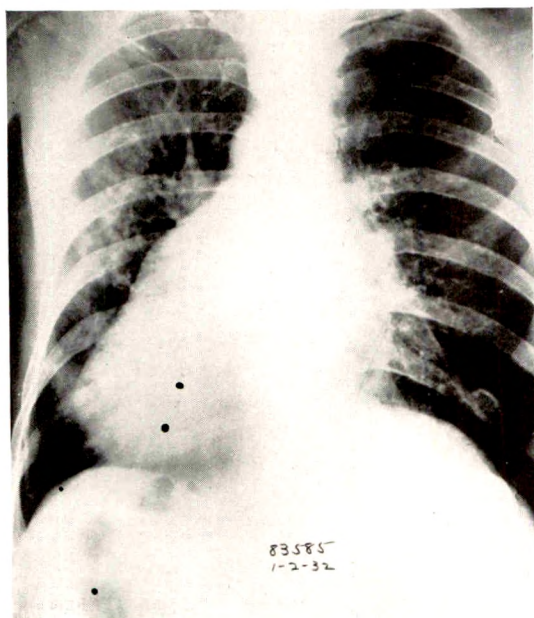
Anterior roentgen examination after injury. No fractures, no evidence of trauma on chest wall; nothing to indicate injury to the lung at this examination.
